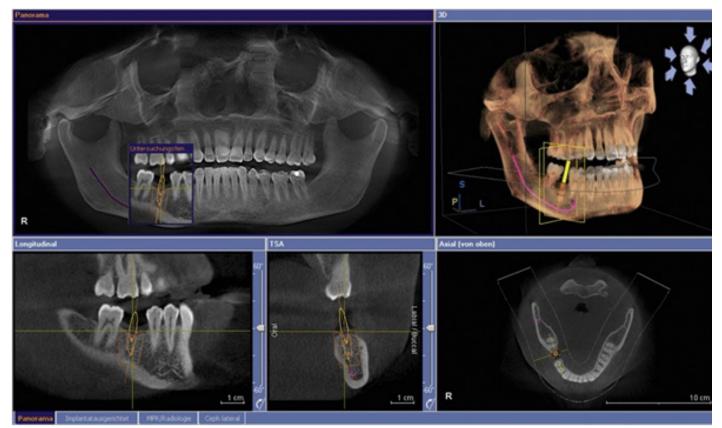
CBCT in dental implant
